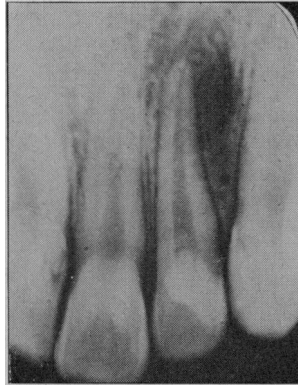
(Case II).—Radiographic appearance of the left lateral incisor similar to that of FIG. 3. This was taken when the patient presented six months later, again with symptoms of an acute apical abscess.
